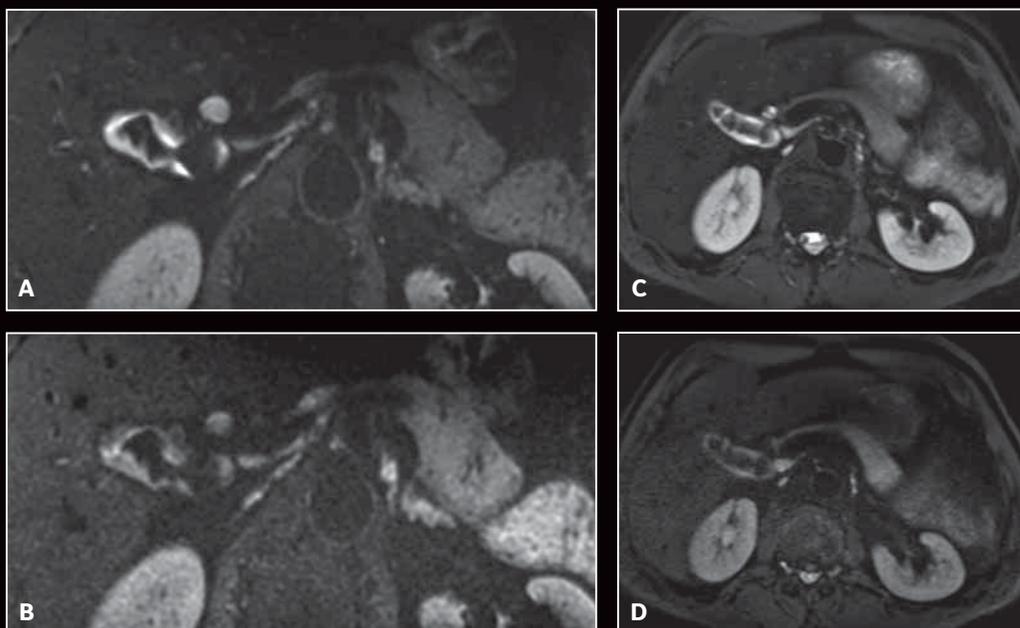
Axial FOCUS DWI at (A) b50 and (B) b500. Axial MUSE DWI (C) b50 and (D) b800.
